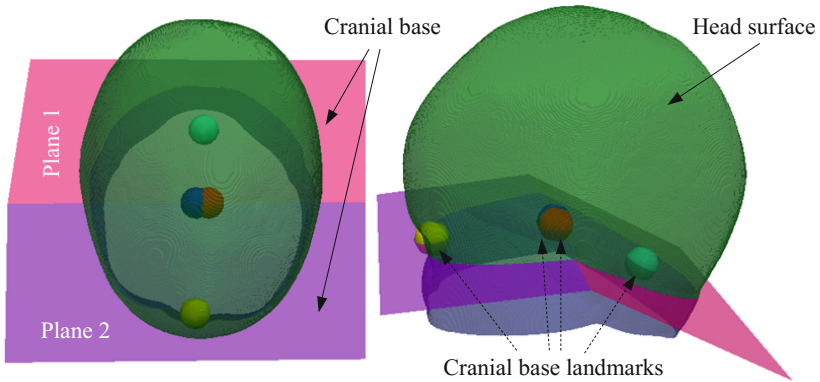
Cranial vault area estimation for head volume measurement. The green surface represents the patient's head surface, which can be obtained from CT or 3D photograph. The cranial base (in purple) corresponds to two planes defined by the 4 cranial base landmarks at the nasion, opisthion and the two clinoid processes of the dorsum sellae. (Color figure online)
